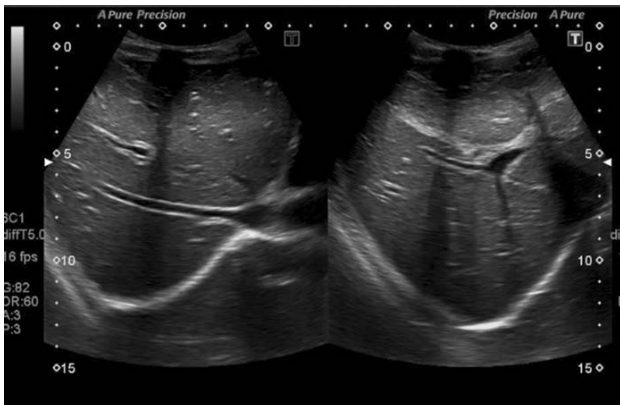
Grey scale image of hepatic ultrasound showing multiple scattered echogenic foci in hepatic parenchyma resembling starry sky in patient with acute hepatitis.
